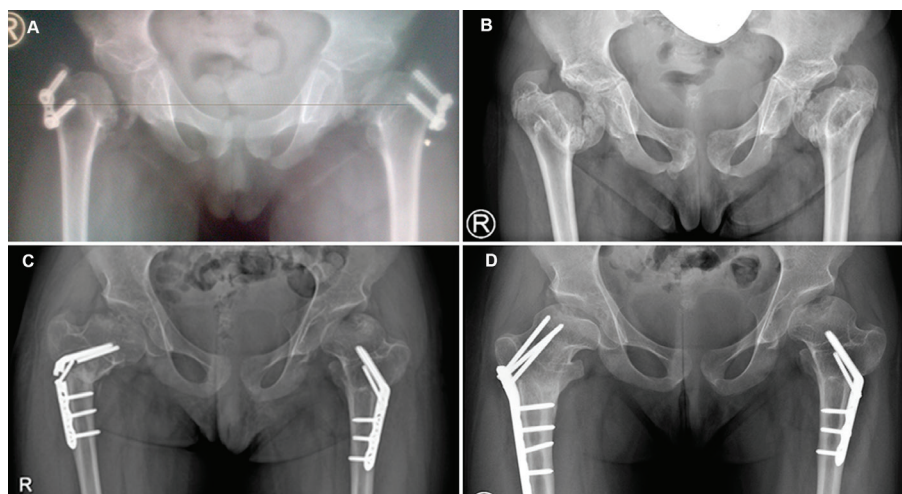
Anterior-posterior X-ray images of both hips in the same patient surgically treated for coxa vara. A) A greater trochanter apo-physiodesis using “Eight plate”. B) Unfavourable results after greater trochanter apo-physiodesis using “Eight plate”. There is still significant varus deformity, ie. intertrochanteric valgus osteotomy was indicated on both hips. C) Incomplete healing of the osteotomy on the right hip leads to implant breakage. Revision surgery was indicated. D) Last follow-up, both hips are with corrected neck-shaft angle. Intertrochanteric osteotomy on the right hip healed completely.
